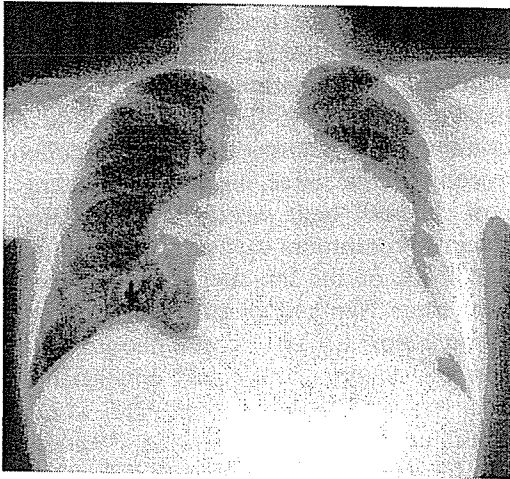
Chest X-ray. Cardiac dilatation and bulging of the right diaphragm can be seen (*arrow*)
